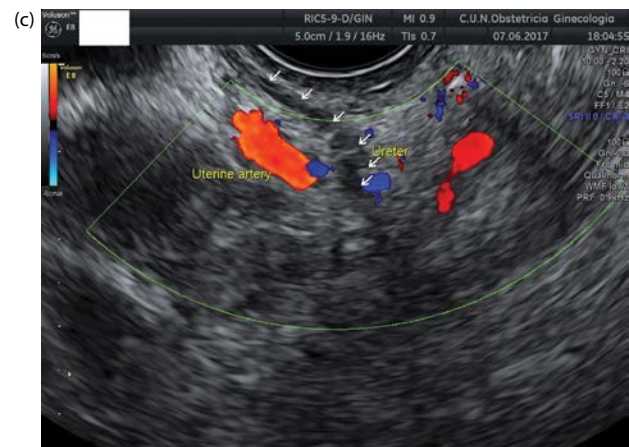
(a) Transvaginal ultrasound showing the bladder. The ureteral meatus can be observed in the longitudinal plane moving the endovaginal transducer laterally. (b) The transmurial portion of the ureter can be observed here as a hypoechoic structure (arrows). In real-time ultrasound, a creeping movement can be seen. (c) Displacing the endovaginal transducer laterally and a little bit anteriorly, the ureter (arrows) can be seen crossing under the uterine artery.
